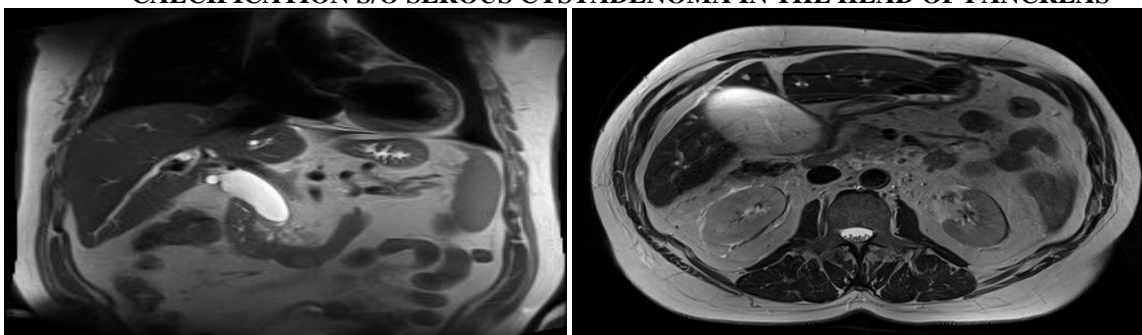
A) CORONAL CE CT B) T2W AXIAL IMAGE SHOW PANCREATIC HEAD MASS (ADENOCARCINOMA)
